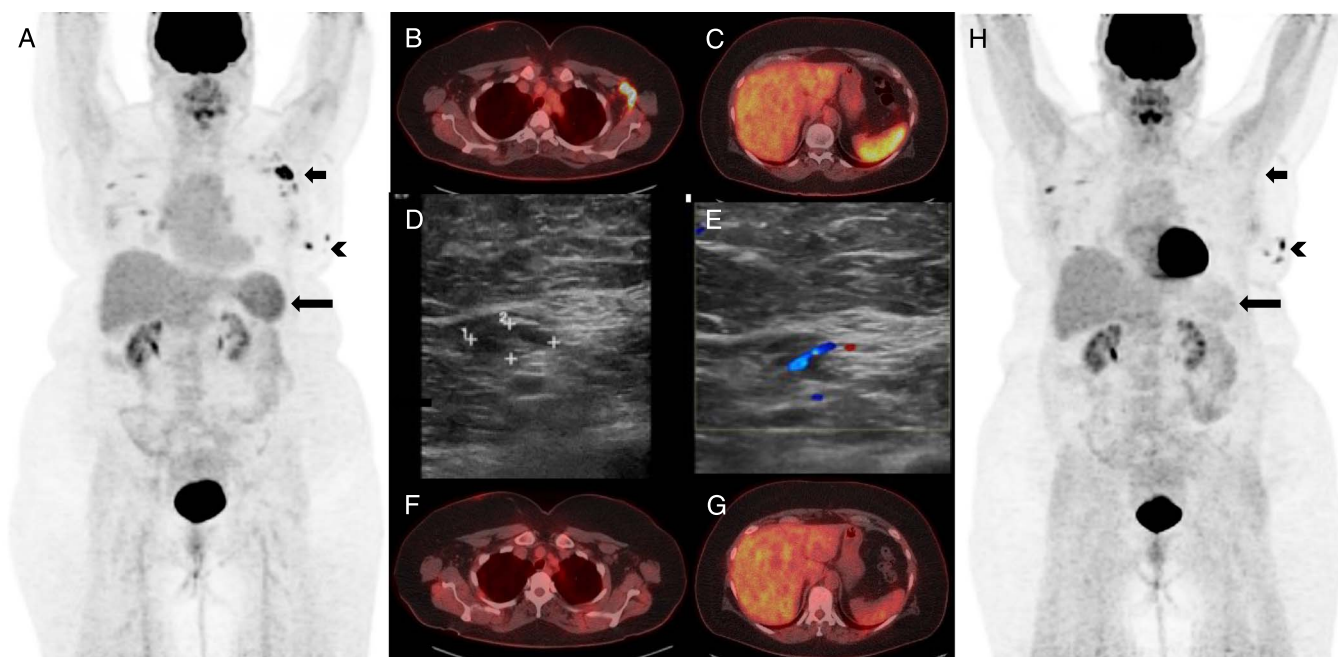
A–H, A 62-year-old woman with bilateral breast nodules underwent biopsy of the left breast lesion, which demonstrated a low-grade B-cell follicular lymphoma. ^{18}F -FDG PET/CT (A–C) was requested for initial staging, which demonstrated bilateral, mildly to moderately FDG-avid breast nodules (arrowhead in A), with the most avid nodule having an SUV_{max} of 7.9. In addition, there were markedly FDG-avid left axillary lymph nodes (short arrow in A and B) with an SUV_{max} of 14.4, which were concerning for lymph nodal lymphomatous involvement. Moreover, there was intense FDG uptake in the spleen (long arrow in A and C) with an SUV_{max} of 5.8, greater than that of the liver, also concerning for lymphomatous involvement. An ultrasound-guided left axillary lymph node biopsy was planned to obtain a definitive diagnosis for initial staging. On the day of the biopsy, approximately 28 days after the ^{18}F -FDG PET/CT; however, no pathologic left axillary lymph nodes were identified. Ultrasound demonstrated a normal-appearing lymph (D, E). The biopsy was hence deferred. Upon further investigation, the patient revealed that she had received COVID-19 vaccination in the left arm 5 days prior to the ^{18}F -FDG PET/CT study. Hence, it was presumed that the intense left axillary lymph nodal and splenic uptake likely represents postvaccination immune response. The follow-up ^{18}F -FDG PET/CT performed 6 months later demonstrated complete resolution of increased FDG uptake in the left axillary lymph nodes and spleen (short and long arrows in H, F and G). There was an overall stable disease in the bilateral breasts (arrowhead in image H). Resolution of abnormal FDG uptake in the left axillary lymph nodes and spleen in the absence of treatment proves causality and self-limiting nature of the immune response to the COVID-19 vaccination. COVID-19 vaccination has been reported to confound ^{18}F -FDG PET/CT interpretation in patients being evaluated for malignancies, particularly lymphoma.¹ Elevated uptake in the ipsilateral axillary lymph nodes after COVID-19 vaccination has also been reported in the literature.^{1–3} Only 2 case reports had shown elevated splenic uptake secondary to COVID-19 vaccination.^{4,5} Another case report had shown increased splenic uptake after influenza vaccination.⁶ This case demonstrates the self-limiting nature of the immune response without any treatment. It also highlights the importance of specific history taking regarding recent vaccination at the time of imaging to safeguard against misinterpretation of such findings. Recently, a similar case was described in a patient with breast carcinoma causing a diagnostic dilemma.^{7,8} With increasing number of people getting booster revaccination, we expect a continued increased prevalence of incidental findings related to COVID-19 vaccination on ^{18}F -FDG PET/CT. It is imperative that nuclear medicine physicians be cognizant of imaging features of immune responses secondary to COVID-19 vaccination during this pandemic to avoid misinterpretations.
